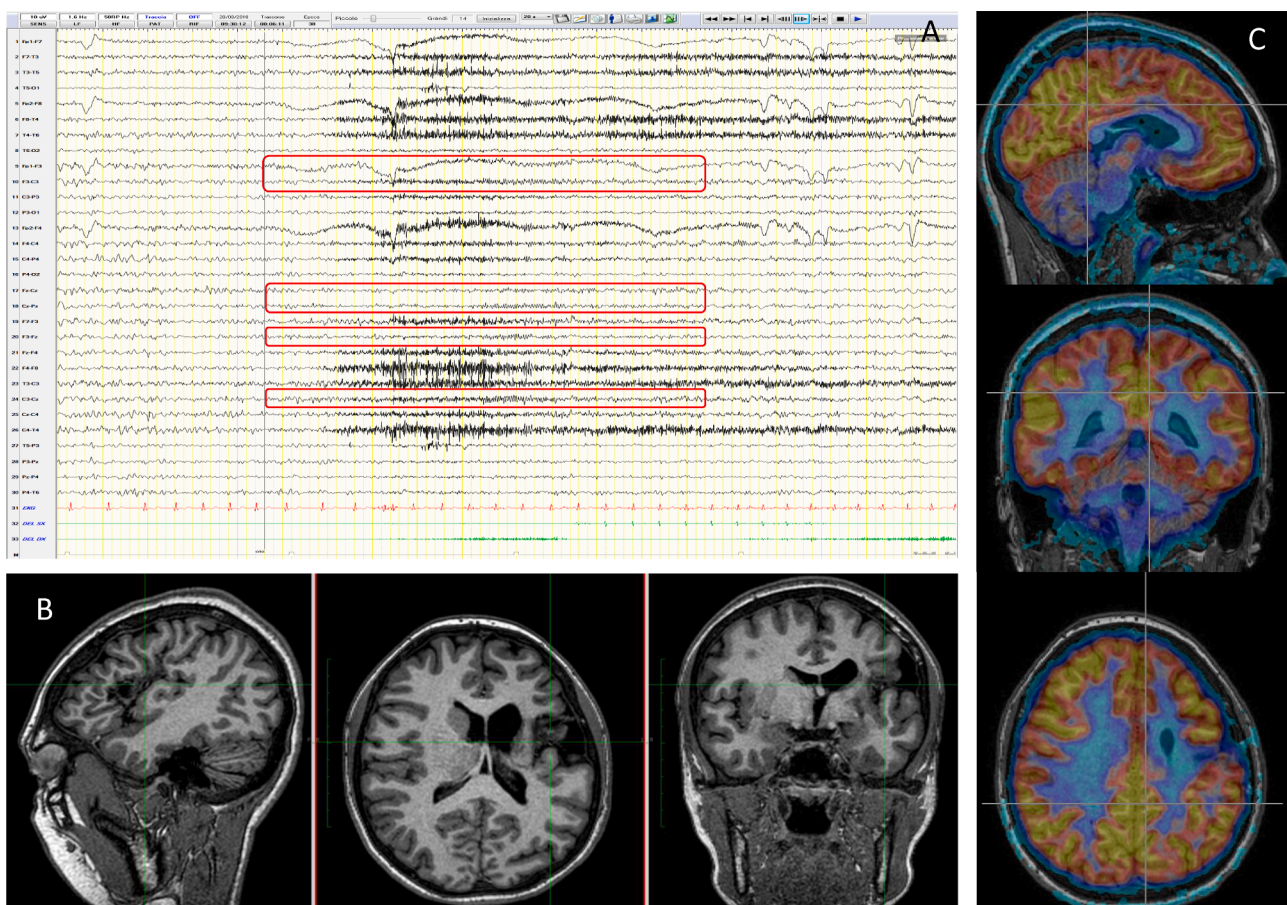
A. Video-EEG Monitoring (LF 1.6 Hz, HF 50 RP Hz, sensitivity $10 \mu\text{V}$): the red rectangles showed the flattening followed by a fast rhythmic discharges over the left fronto-central leads including the vertex during a typical spontaneous seizure. The clinical onset corresponded to the appearance of muscles artifacts. 1B - 3D-T1 MRI (sagittal, axial, coronal planes): cortico-subcortical malacic lesion in left insular and dorso-frontal regions. 1C - FDG-PET (from the top to the bottom, sagittal, coronal and axial planes): hypometabolic region around the malacic lesion, the surrounding cortex had a normal metabolism, mostly over the left posterior and frontal cortex.
